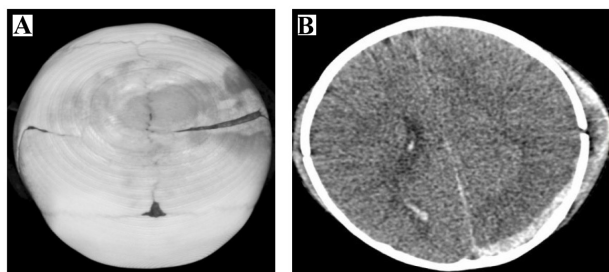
(A) 3D computed tomography scans of child with two parietal fractures. (B) CT scan axial view, same child, subdural hematoma in occipital lobe.
